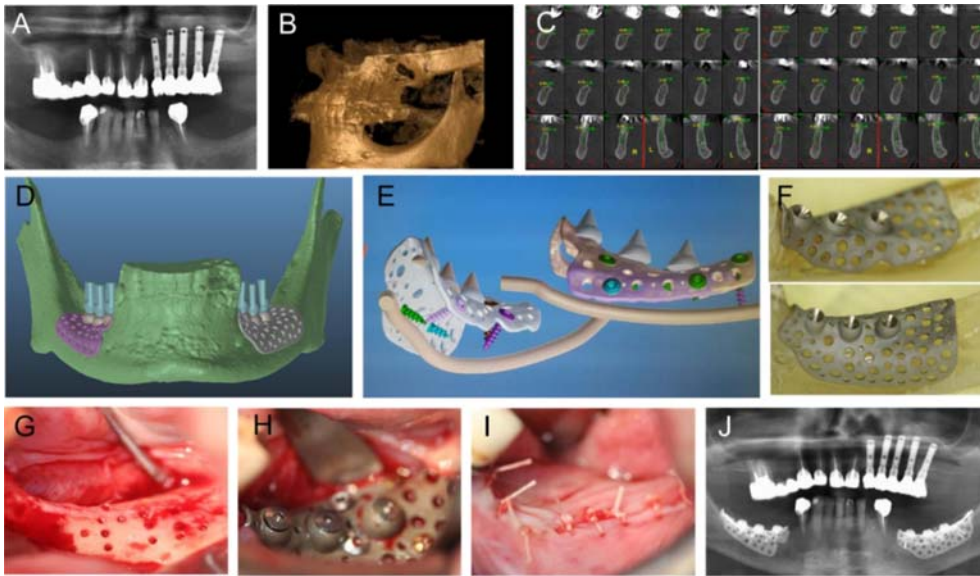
A second case of a patient customized endosteal implant. A CT scan was taken of the patient (A) to plan implant placement (B, C). Customized Ti6Al4V implants were designed using software (D, E). The implants were manufactured as one piece for each side. For each implant, small holes were drilled into the patient's jaw prior to implant placement to ensure exposure to stem cells and progenitor cells (G), the implant was placed and stabilized (H) and the gum and periosteum were sutured over the implant (I). A follow-up panoramic X-ray was taken to evaluate osseointegration and the bone to implant contact after three months (J).
